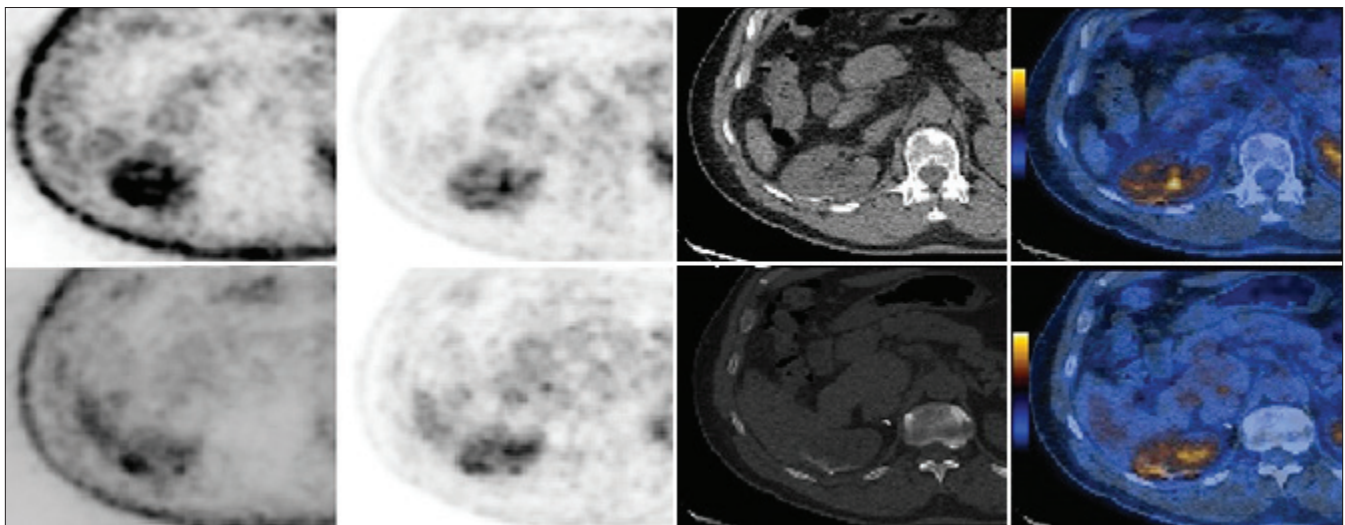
FDG PET/CT images showing the recurrence of PRCC along the surgical margins after partial nephrectomy
